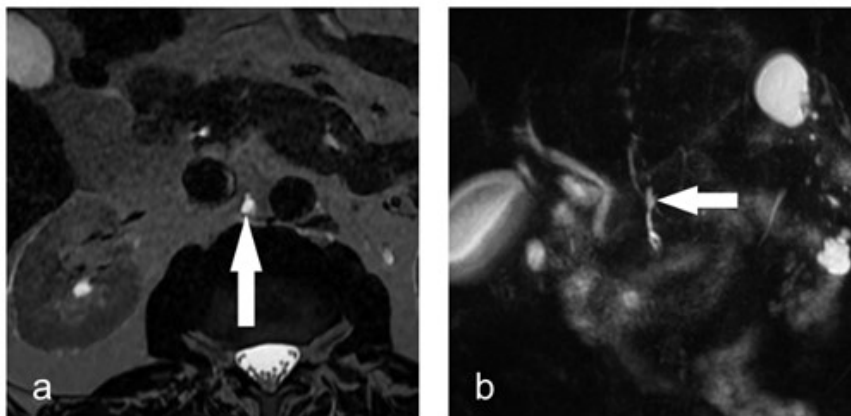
Normal CC in a 65-year-old male with BRCA2 cancer predisposition undergoing MRCP for surveillance. Axial 2D (1.5T, TR 2210.52 ms, TE 250.9 ms) MR image (a) and coronal 3D MIP (1.5T, TR 6666.67 ms, TE 700.6 ms) MR image (b) demonstrate a normal CC (arrows).
